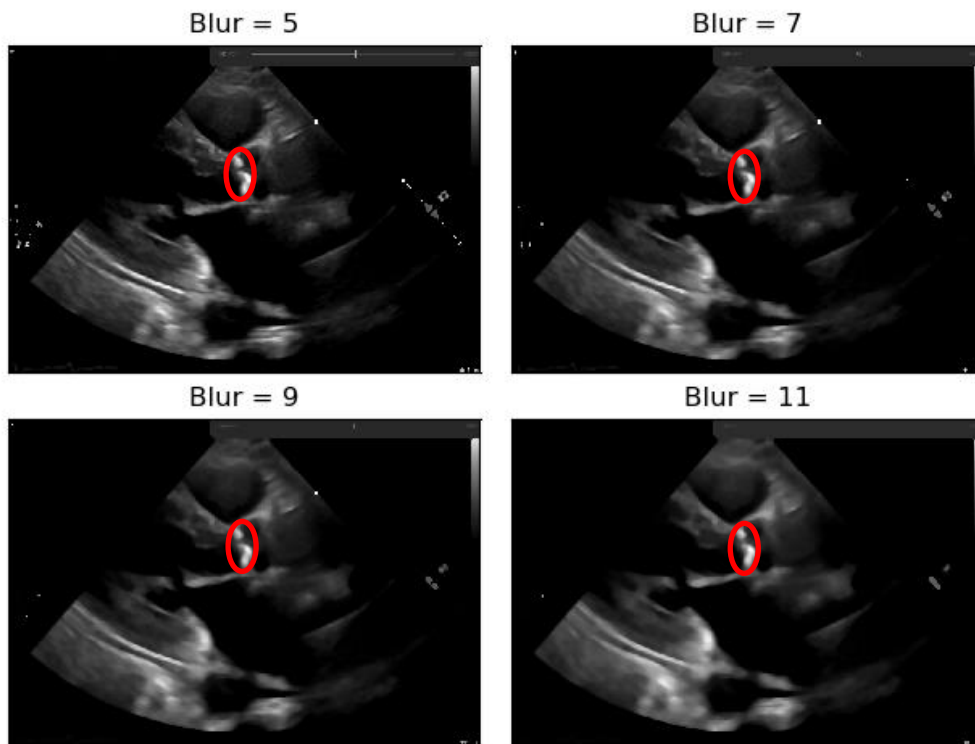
Echocardiography image with four levels of blurring applied
